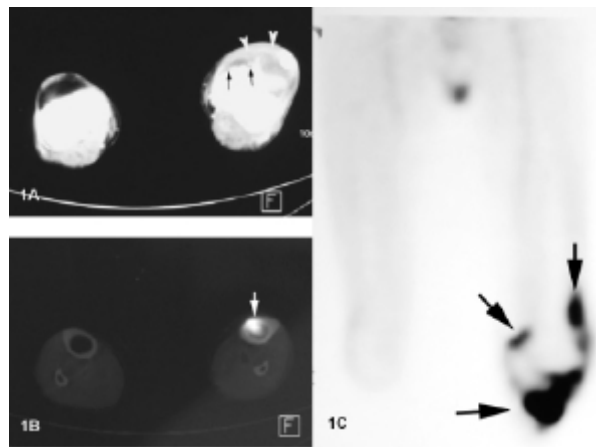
(A) Axial CT scan showing soft tissue synovial mass (arrowhead) arising in the left knee joint with bony destruction of the femoral condyles (arrows). (B) Axial fused PET-CT image showing abnormal uptake in the left tibia (arrows) (C) PET scan image showing multiple focal uptake around the left knee joint compatible with synovial soft tissue mass.
